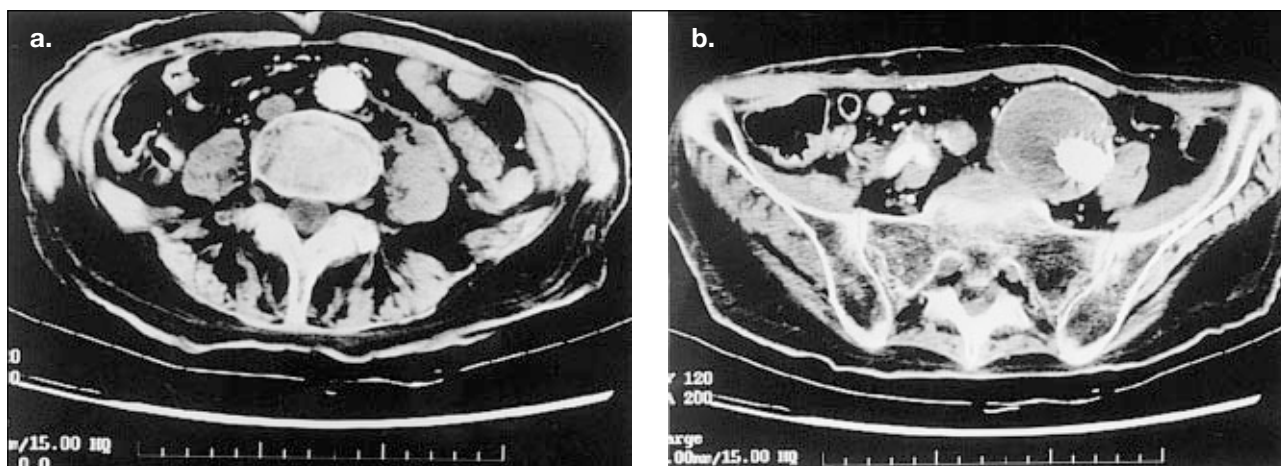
Computed tomography scan of the abdomen and pelvis 1 month postsurgery
